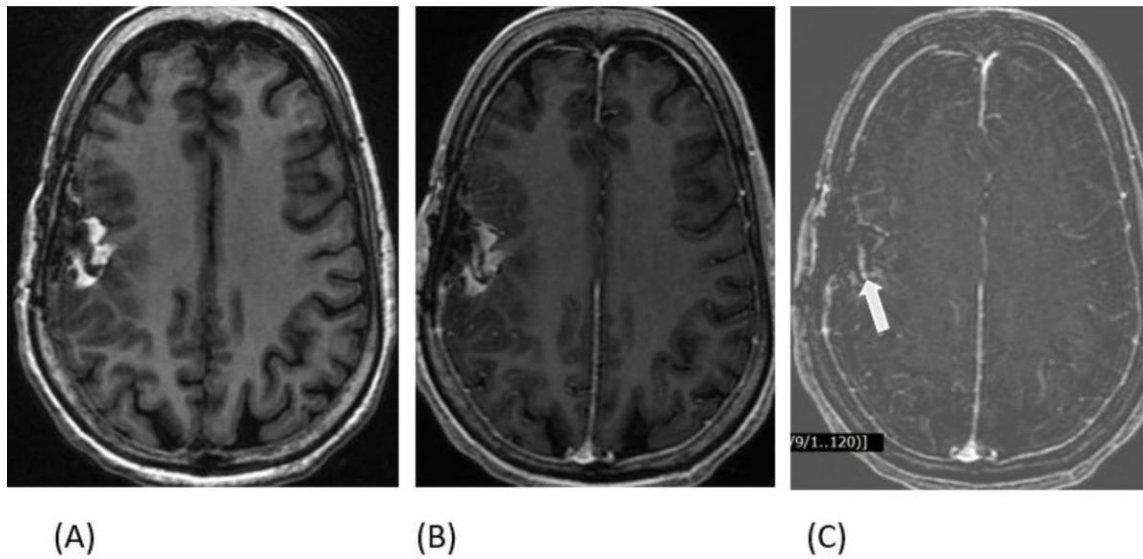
1 Post-Operative follow up MRI of right fronto-temporal low-grade glioma in 65 years old shows A) Unenhanced T1-weighted image shows right postsurgical changes with hyper intense area consistent with subacute hemorrhage. B) Contrast-enhanced T1 -weighted image of same slice shows mild enhancement along the posteromedial aspect of lesion, however that is difficult to distinguish from adjacent hemorrhage. C) Subtraction of A from B clearly shows posteromedial nodular enhancement (arrow) consistent with residual tumor. Rest of the areas shows signal void with linear peripheral enhancement – s/o post-operative changes. Two patients with intraparenchymal T1 hyperintense brain lesions with indeterminate post contrast enhancement showed no enhancement in one case and linear enhancement in another case on subtracted images, suggestive of intraparenchymal hemorrhage (IMAGE 2).
